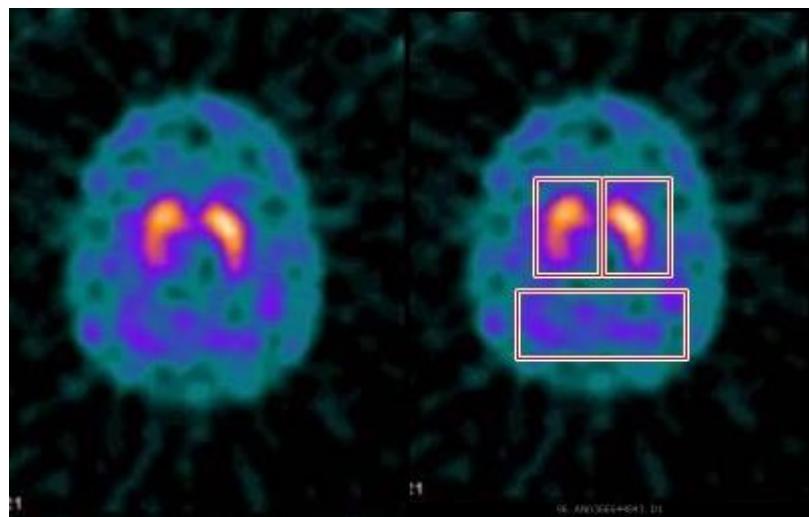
Cuantificación SPECT [^{123}I]-loflupano mediante ROIs.
